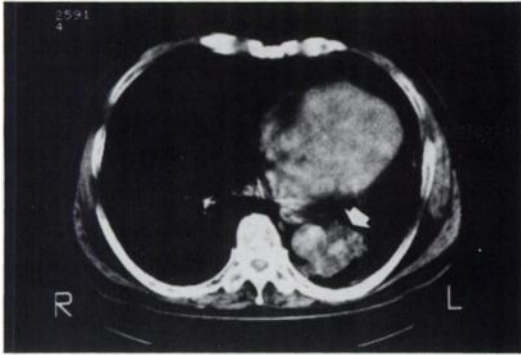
Precontrast computed tomogram depicted a tumor mass next to the aorta (white arrow).
